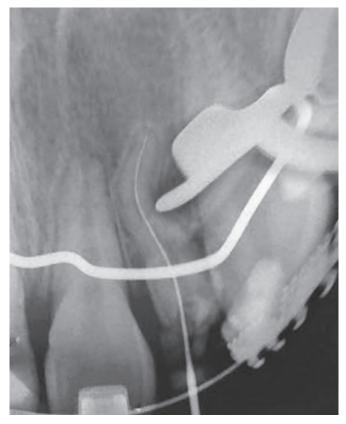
Odontometry periapical radiography.
